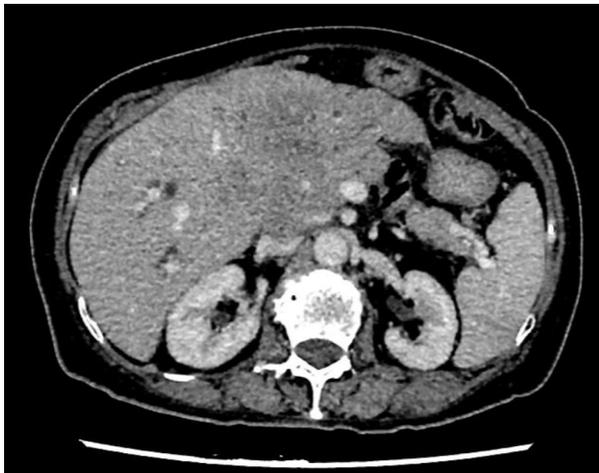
Axial contrast-enhanced computed tomography image of the abdomen showing an ill-defined, hypoenhancing infiltrative mass involving both hepatic lobes (white arrows), occupying segment II, III, IVa, IVb, V and VIII. The lesion demonstrated vascular encasement with mild intrahepatic ductal dilatation
